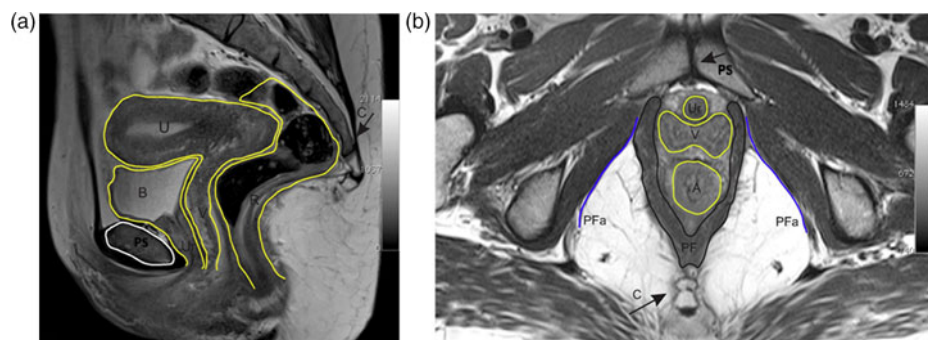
Magnetic resonance images in the sagittal (a) and axial (b) planes, where the surfaces of the some pelvic structures were identified and delineated. (A – anus; B – bladder; C – coccyx; PF – pelvic floor muscles; PFa – pelvic fascia; PS – pubic symphysis; R – rectum; Ur – urethra, V – vagina)
